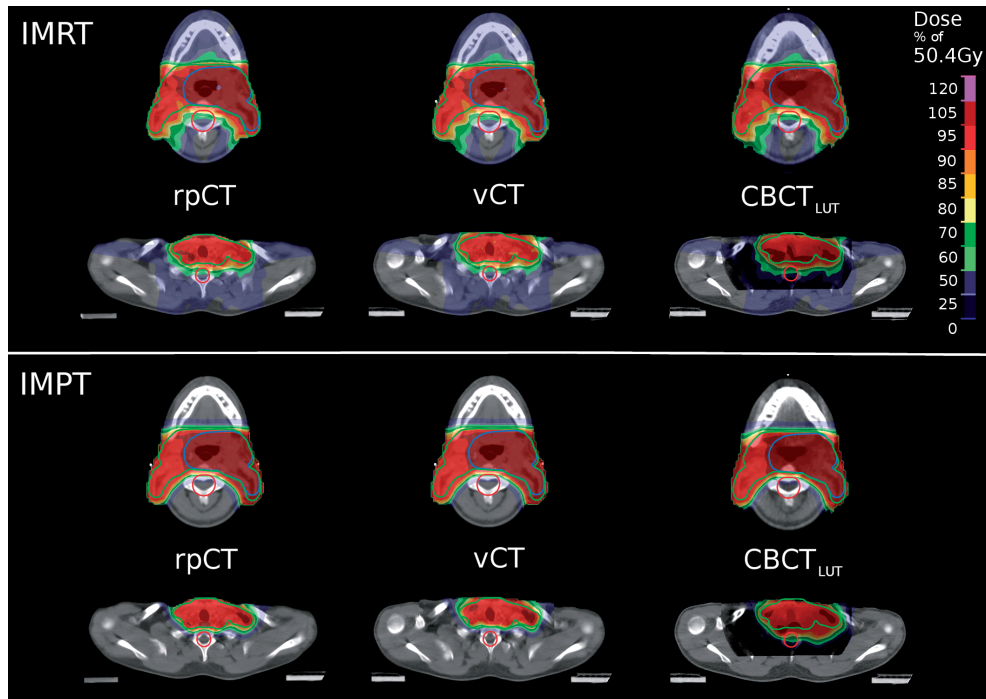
2D IMRT (top part) and IMPT (bottom part) dose distributions (color-wash) on the investigated CT datasets for PatCA6 in an upper (top row of each part) and lower (bottom row) axial slice. The low and high dose PTVs (green and blue structures), as well as the spinal cord planning organ at risk volume (PRV, red structure) are also shown.
